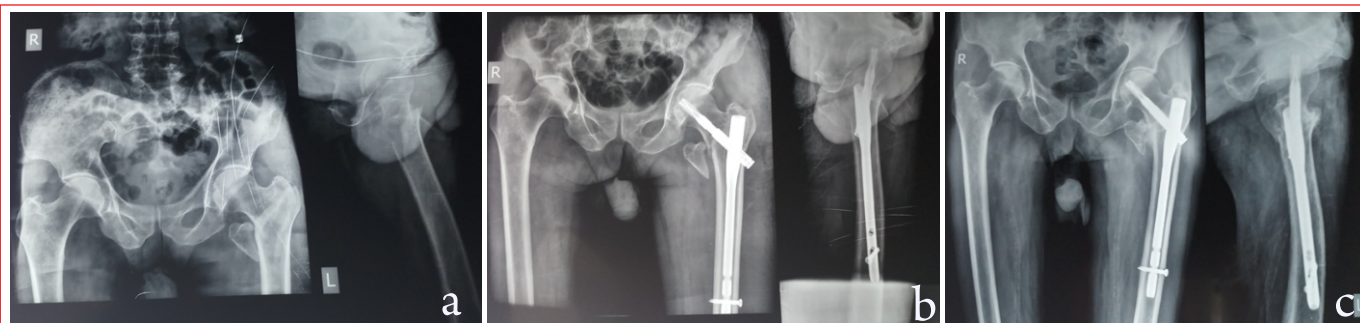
1a: Radiograph of 80-years male with AO 31A2 fracture of left hip, 1b: He was treated with CRIF with Short CMN, 1c: Follow-up radiograph at 1 year showing complete union
